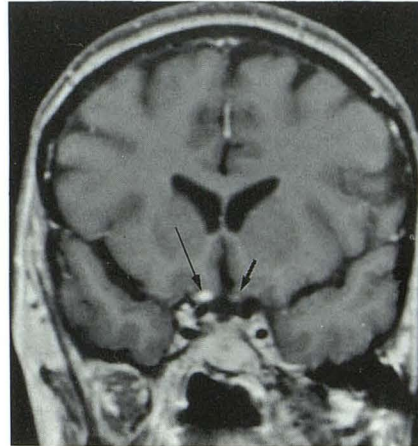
Coronal enhanced T1-weighted image shows the normal nonenhancing prechiasmatic optic nerve on the left (*short black arrow*) and the enhancing right optic nerve (*long black arrow*).
